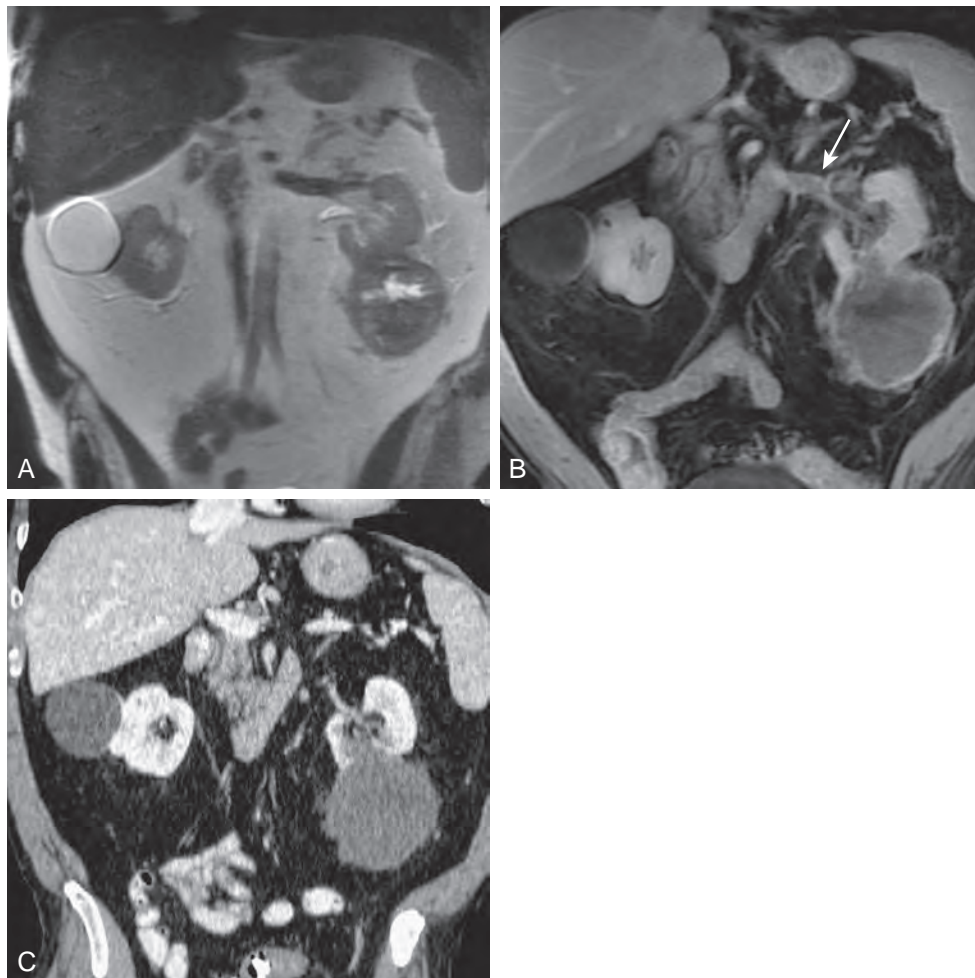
Renal cell carcinoma on pre- and postcontrast magnetic resonance image (MRI) and contrast-enhanced computed tomography (CT). A, Precontrast, T2-weighted MRI showing a simple cyst in the right kidney and heterogeneous 8.5 cm, lower pole tumor in the left kidney. B, Postcontrast, fat-saturated, T1-weighted MRI reveals further anatomic details regarding the left renal tumor, including a tumor thrombus (arrow) within the renal vein not reaching the inferior vena cava. C, Contrast-enhanced CT imaging (parenchymal phase) from the same patient also shows the left renal tumor. MRI was performed in this patient because of equivocal findings on the initial CT scan regarding a renal vein thrombus, which was seen clearly on both pre- and postcontrast MRI. (Courtesy Dr. Leena Mammen, Grand Rapids, MI.)
